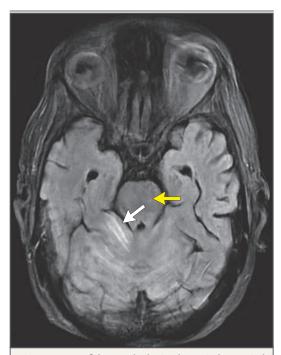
MRI of the Head Obtained on Ninth Hospital Day.
